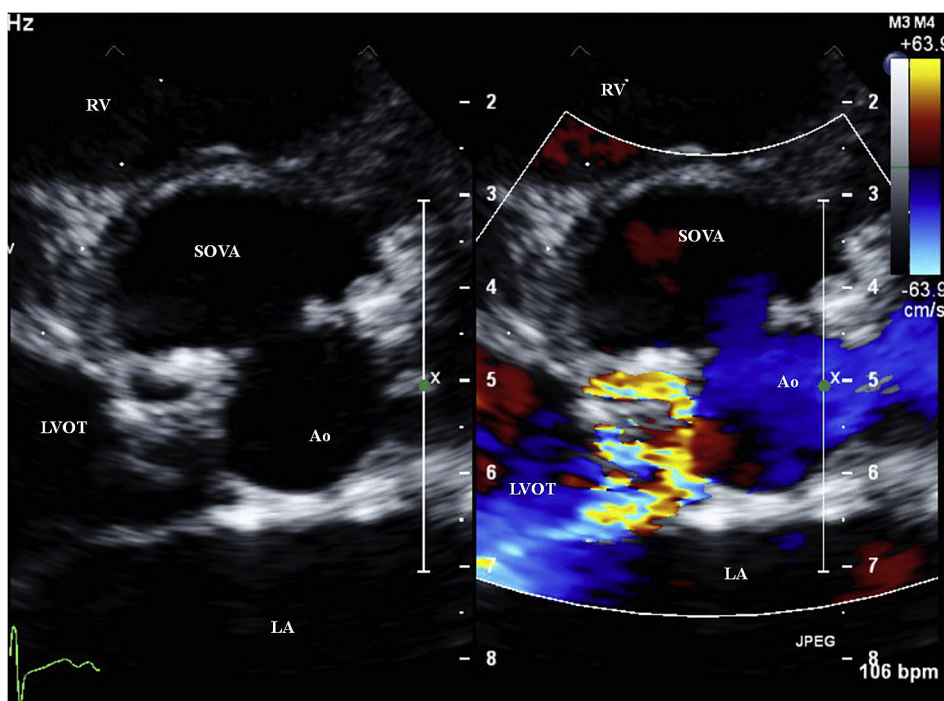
Transthoracic echocardiography in parasternal short axis view showing the site of communication of aneurysm with the aortic sinus. LA – Left atrium, LVOT – Left ventricular outflow tract, RV – Right ventricle, Ao – Aorta, SOVA – Sinus of valsalva aneurysm.
